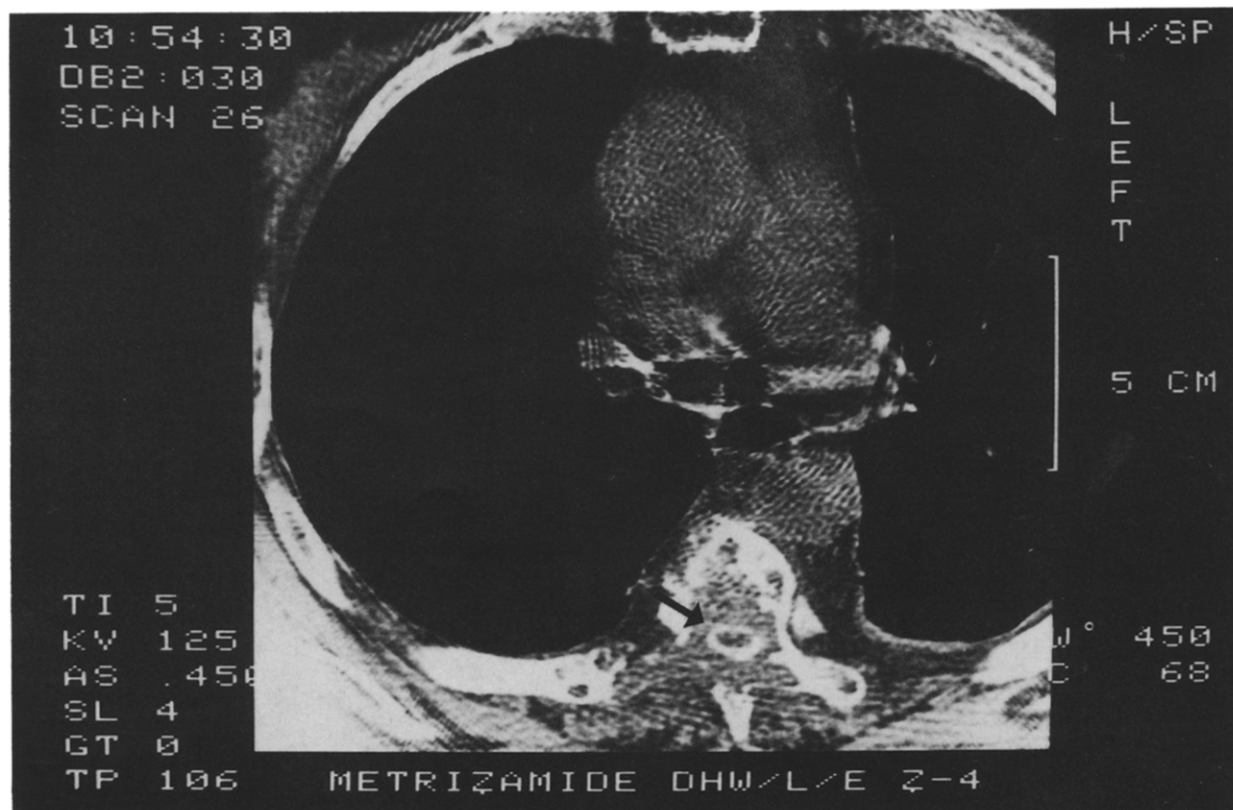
Out-patient CT myelography in patient #3 reveals extensive destruction of T5 with epidural tumor (arrow) surrounding the contrast filled subarachnoid space.
